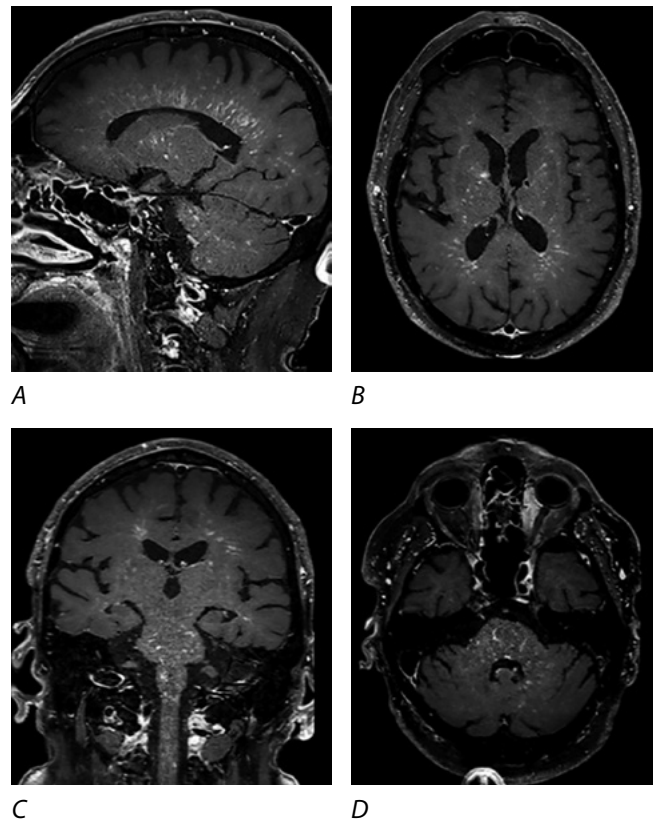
Patient M.'s brain MRI (November 2022). T1+C: contrast enhancement in the periventricular and deep white matter of the cerebral hemispheres (A–C), the brainstem (C, D), the cerebral peduncles (D), and both cerebellar hemispheres (A, D).
